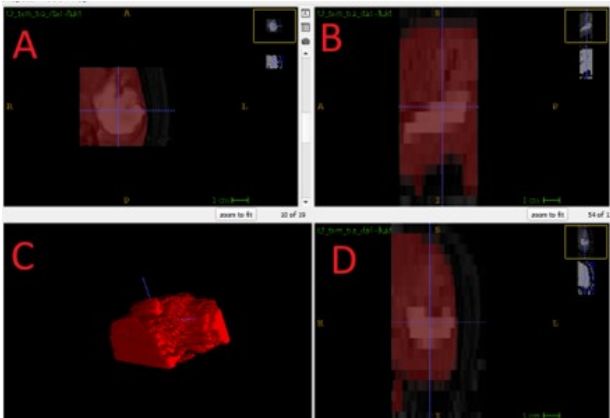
This figure demonstrates the 3D segmentation of brain tumors using ITK-SNAP. (A) Irregular tumor boundary, (B) extracted MRI image, (C) 3D tumor model, (D) clustering of segmented tumor area. The process visualizes tumor volume and shape effectively.
